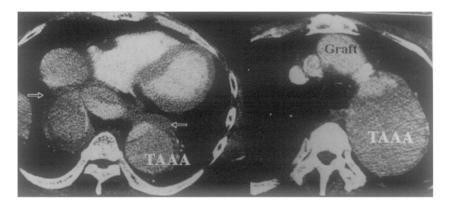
Computed tomography before last operation. *Right*, Large thoracoabdominal aortic aneurysm (*TAAA*) occupied left hemithorax. *Graft*, Arch graft of previous procedure. *Left*, At peridiaphragmatic portion, tortuous TAAA traversed from left pleural cavity to right. Marked periaortic fibrosis was noted (white arrows).
